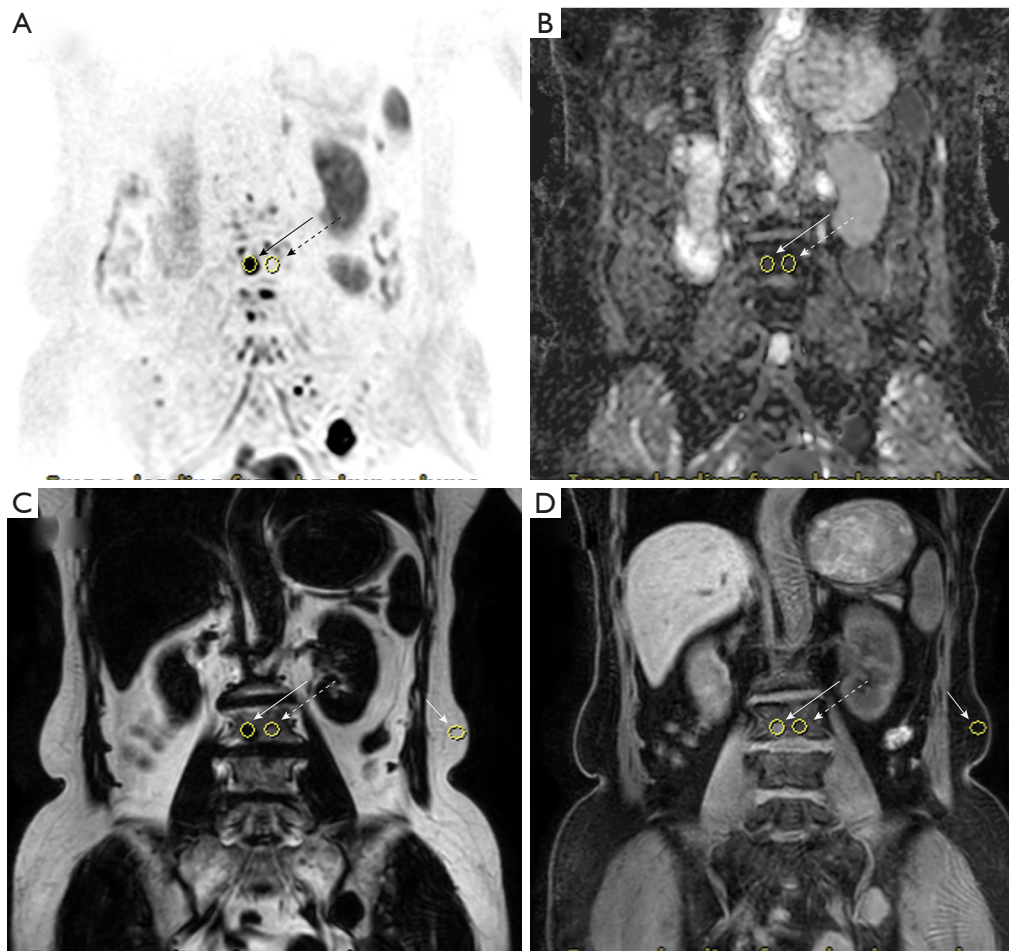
Images in a 65-year-old woman with multiple myeloma. (A) Coronal DWI image of the thoracolumbar spine with ROI of the FLs (the solid arrow) and NABM (the virtual arrow). The fat in the same phase direction with lesion was chosen as an internal reference to normalize the signal of Dixon. The ROI position of fat was also shown; coronal ADC image (B), fat phase (C), and water phase image (D) of the thoracolumbar spine. ROIs of the FLs and NABM located in the same position with those in DWI image. DWI, diffusion-weighted imaging; ROI, region of interest; FLs, focal lesions; NABM, normal appearing bone marrow; ADC, apparent diffusion coefficient.
